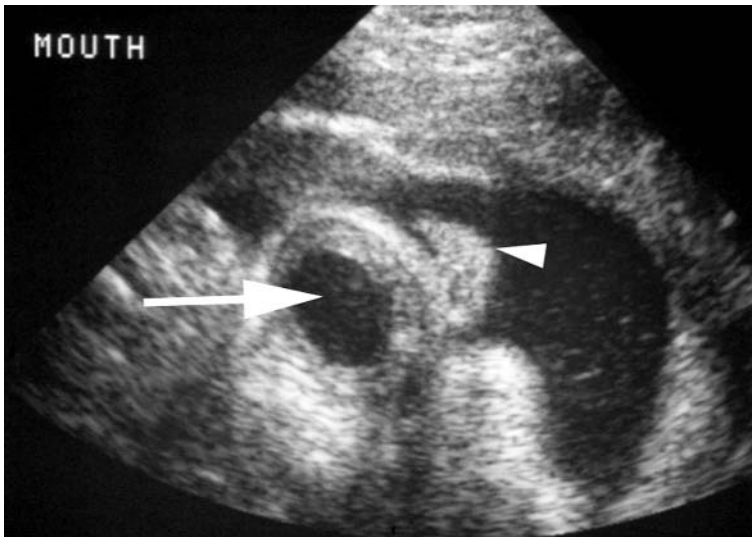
Prenatal ultrasound of salivary cyst of oral cavity. Coronal plane. The salivary cyst (*arrow*) is the hypoechoic area spreading the lips outward preventing mouth closure. Tip of nose (*arrowhead*). With permission from Doubilet PM, Benson CB (2003) Atlas of ultrasound in obstetrics and gynecology: a multimedia reference. Lippincott Williams & Wilkins, Philadelphia
